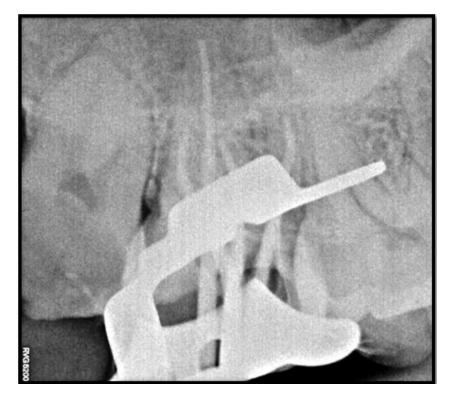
(Master Cone X-Ray)
